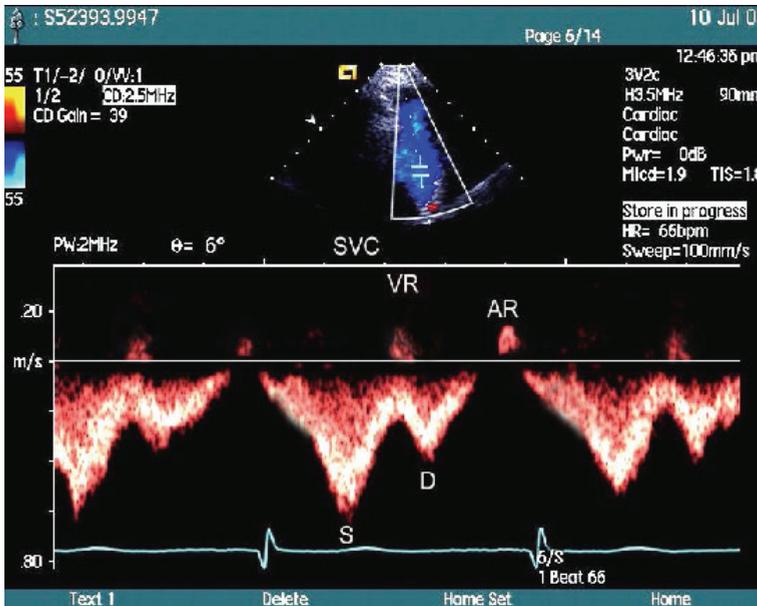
SVC Doppler flow spectra in healthy subjects. Doppler interrogation of the SVC shows systolic and diastolic phases of flow (S- and D-waves) toward the heart and late ventricular systolic and atrial systolic phases of backward flow (VR- and AR-waves)
